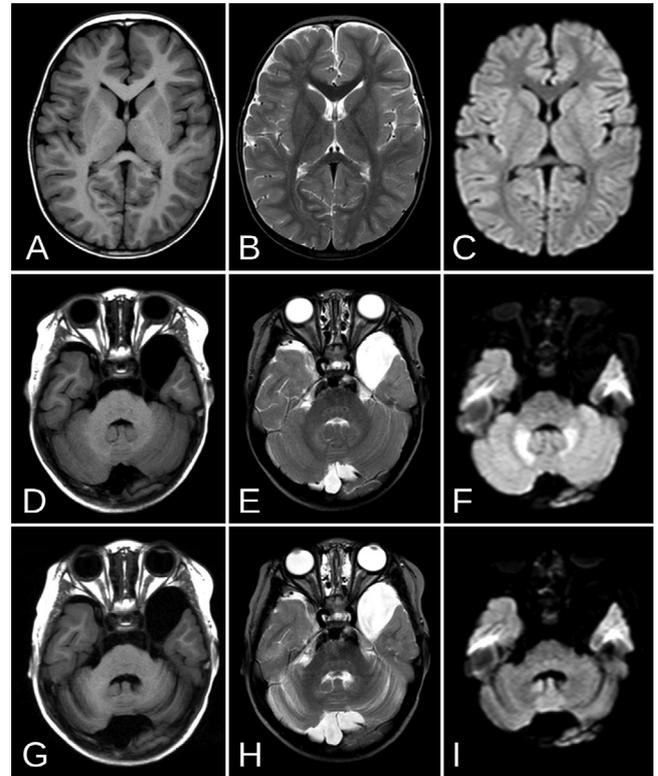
Magnetic resonance findings of our patient on day of illness (DOI) 4 (A–F) and DOI 135 (G–I): left column, T1-weighted images (A, D, and G); middle column, T2-weighted images (B, E, and H); and right column, diffusion-weighted images (C, F, and I). On DOI 4, cerebral images (A–C) do not show any abnormality; however, cerebellar images (D–F) show abnormal intensities in the bilateral cerebellar nuclei: namely the dentate nuclei, which are prominent in the diffusion-weighted image (F). The involvement of other cerebellar nuclei, such as fastigial, globosus, and emboliform nuclei, is not apparent. On DOI 135 (G–I), cerebellar atrophy is evident.
